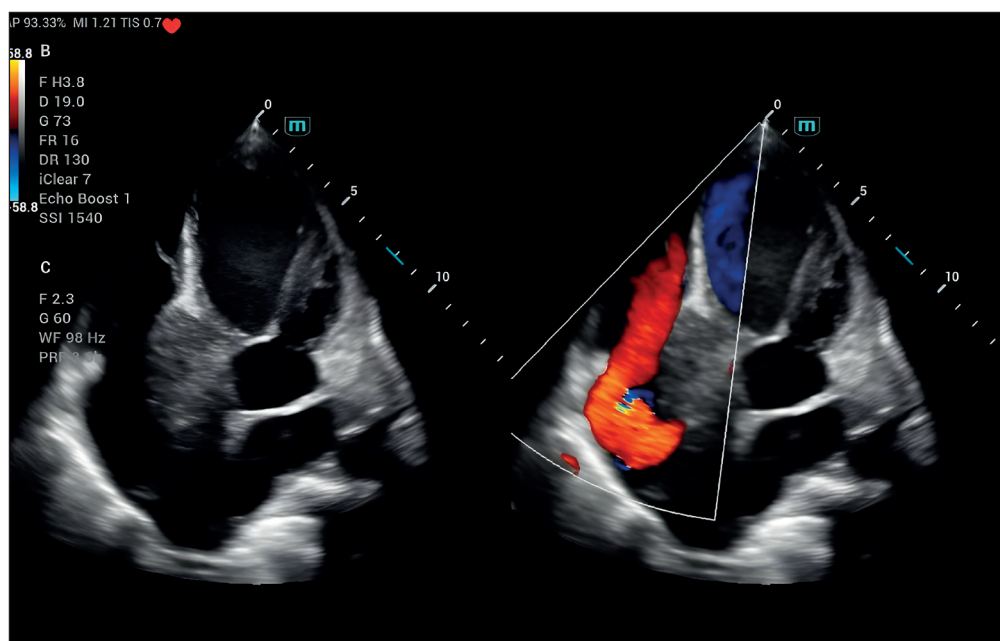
2D transthoracic echocardiography showing mass in right atrium, interatrial septum, and left atrium.
